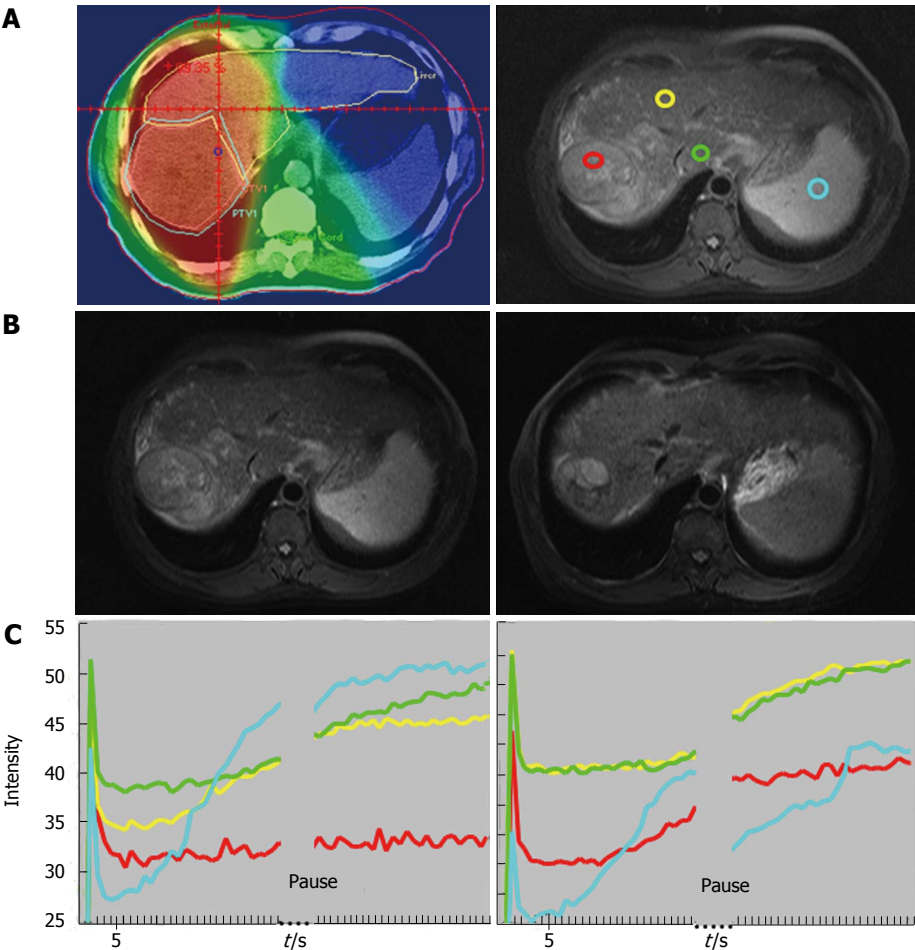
Forty-nine-year-old man with good local response. A: Isodose distribution and region of interests (ROIs): Left panel: Isodose distribution on center section of radiation treatment planning. Red: 45 Gy; orange: 40 Gy; yellow: 30 Gy; green: 15 Gy and blue: < 15 Gy. Right panel: ROIs on MRI before RT: red: tumor with strongest enhancement; yellow: non-tumor liver parenchyma receiving 30 Gy; green: non-tumor liver parenchyma receiving 15 Gy; blue: spleen; B: T1 weighted contrast-enhanced MRI before RT (left panel, the site corresponding to the right panel of (A) and after RT (right panel). Arrows indicate tumor margins; C: Time Intensity Curve of ROIs before RT (left panel) and at week 2 of RT (right panel). Red: tumor; yellow: 30 Gy; green: 15 Gy; blue: spleen. The curve of spleen is deviated after pause for respiration due to interference by lung perfusion. The initial spike due to refocusing artifact will not be counted into analysis. (From reference [23], reprint with permission).
